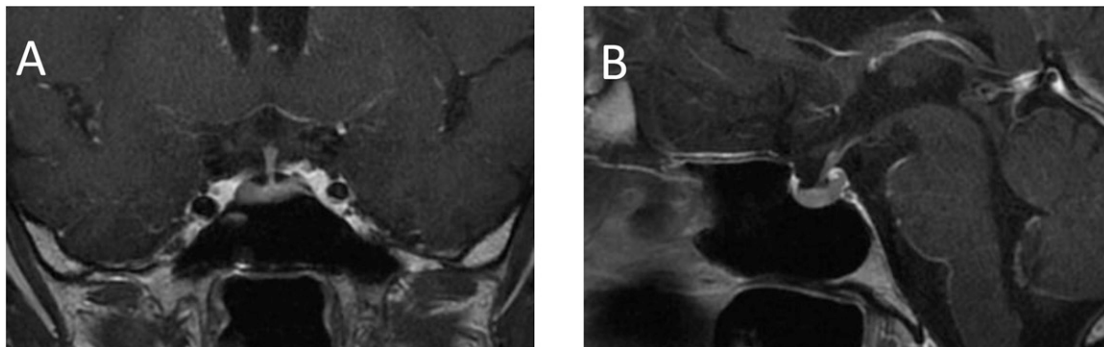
MRI with gadolinium contrast showing a normal-sized pituitary and stalk and normal enhancement. (A) Coronal image; (B) sagittal image.
